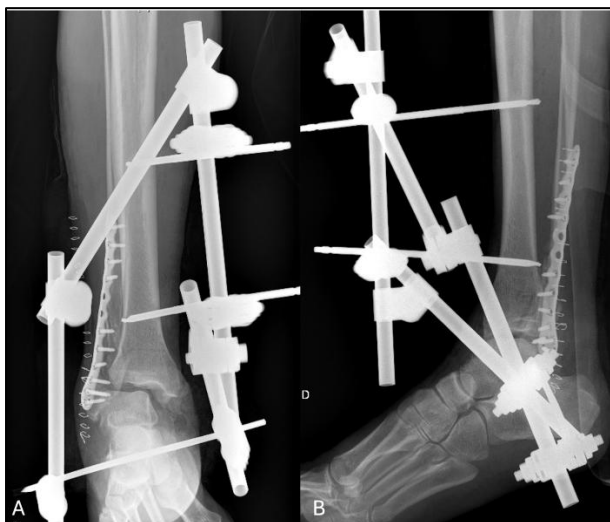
(A) Anteroposterior and (B) lateral radiographs after lateral fibular plate and temporary stabilization with an external fixator with a persistent anterolateral dislocation of the talus and widening of the medial clear space.
